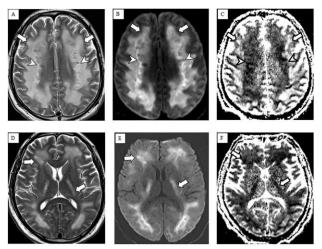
Non-contrast brain MRI. Multiple axial images including T2-weighted (A and D), diffusion-weighted (B and E) and apparent diffusion coefficient (C and F) images demonstrate symmetric confluent supratentorial white matter T2 hyperintensities extending into the internal capsules (arrows in A, D) sparing the subcortical U fibers and deep gray nuclei. Notably, there is reduced diffusion in the more central white matter (arrowheads in B, C) with geographic margins and corresponding internal T2 heterogeneity (arrowheads in A), suggesting areas of active demyelination and necrosis. Susceptibility-weighted images (not shown) did not show any appreciable blood products.
